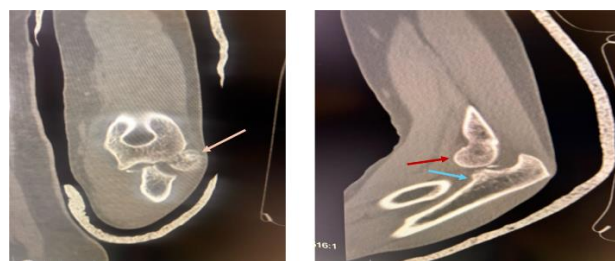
CT images highlighting the terrible triad injury. Radial head fracture (Pink); Coronoid fracture (Blue) and subluxation of elbow joint (Red)
